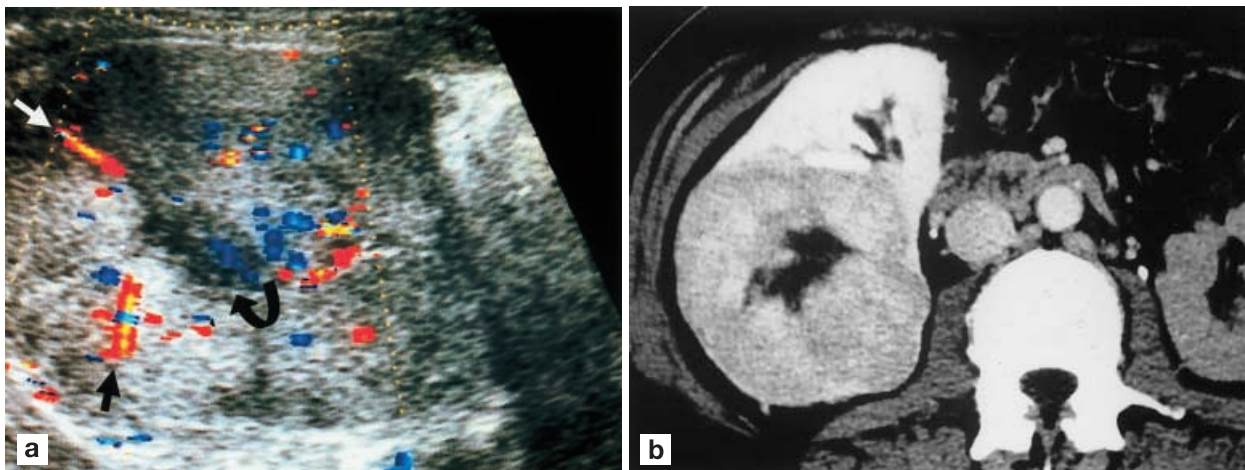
Large RCC. a Ultrasound shows a large heterogeneous solid renal tumor (*arrows*) within the lower pole of the right kidney. b Contrast-enhanced CT demonstration of a typical large necrotic RCC
